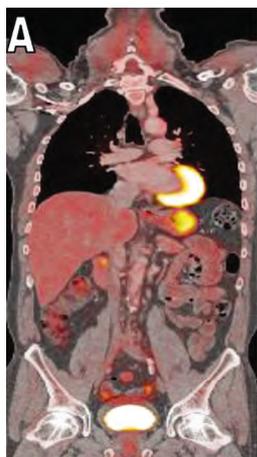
A 59-year-old male patient having a right SPN accidentally discovered by CT. (A & B) whole body combined PET/CT scan and contrast enhanced axial CT, PET & combined PET/CT images performed as a baseline study, (C) follow up contrast enhanced axial CT, PET & combined PET/CT images 6 month later. It showed no significant metabolic or morphologic changes regarding the previously noted right lung lower lobe apical segment well defined non calcified pulmonary nodule that is still measuring about 1.2 cm with SUVmax 2.0 in the follow-up study as seen in (C). Additionally, no evidence of 1ry neoplasm along the whole body scan to suggest a metastatic possibility for that SPN.
